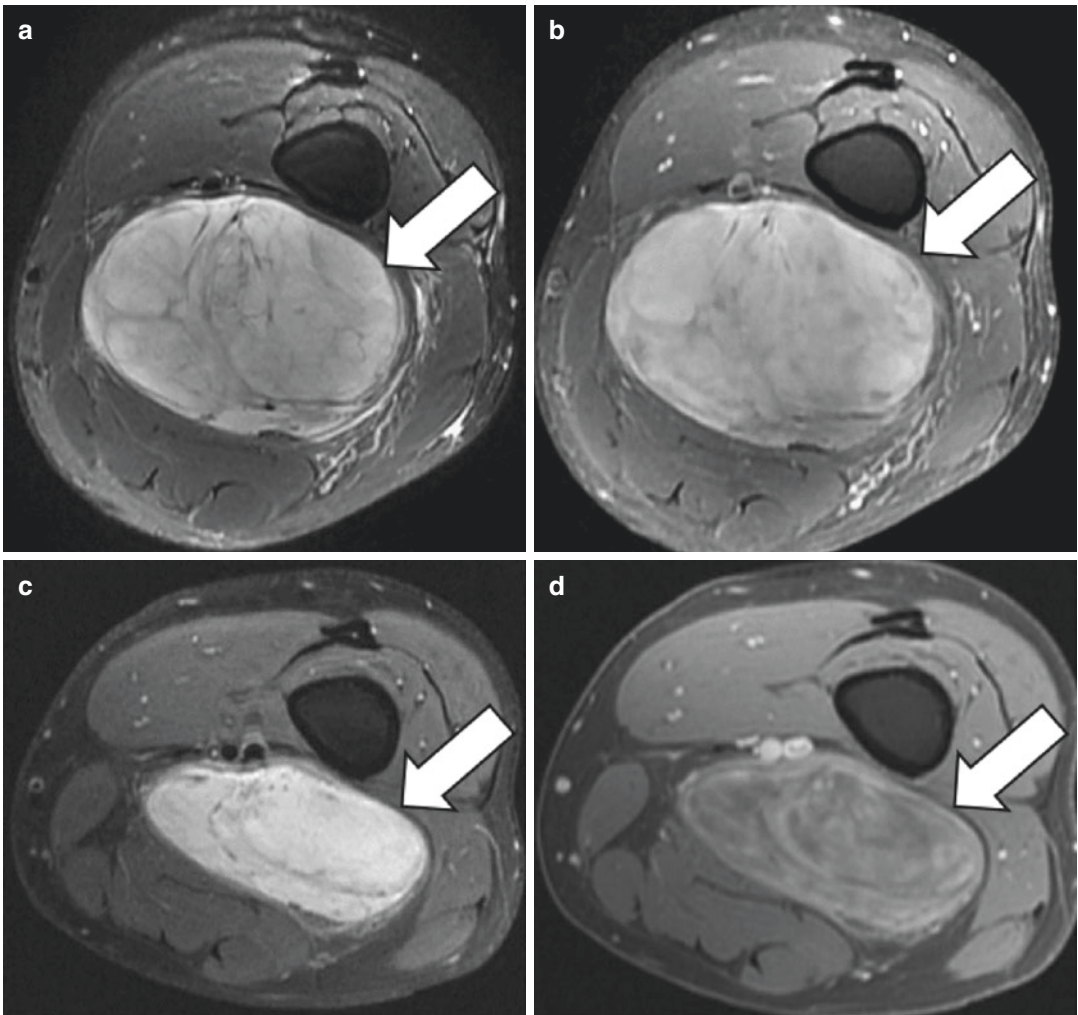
51-year-old man with myxoid liposarcoma of the left thigh treated with neoadjuvant chemoradiation therapy. (a, b). Axial short-tau inversion recovery (STIR) and post-gadolinium fat-suppressed T1-weighted images demonstrate T2 hyperintense mass in the posterior compartment of the thigh (arrow) which shows intense homogeneous enhancement after contrast administration. (c, d)
